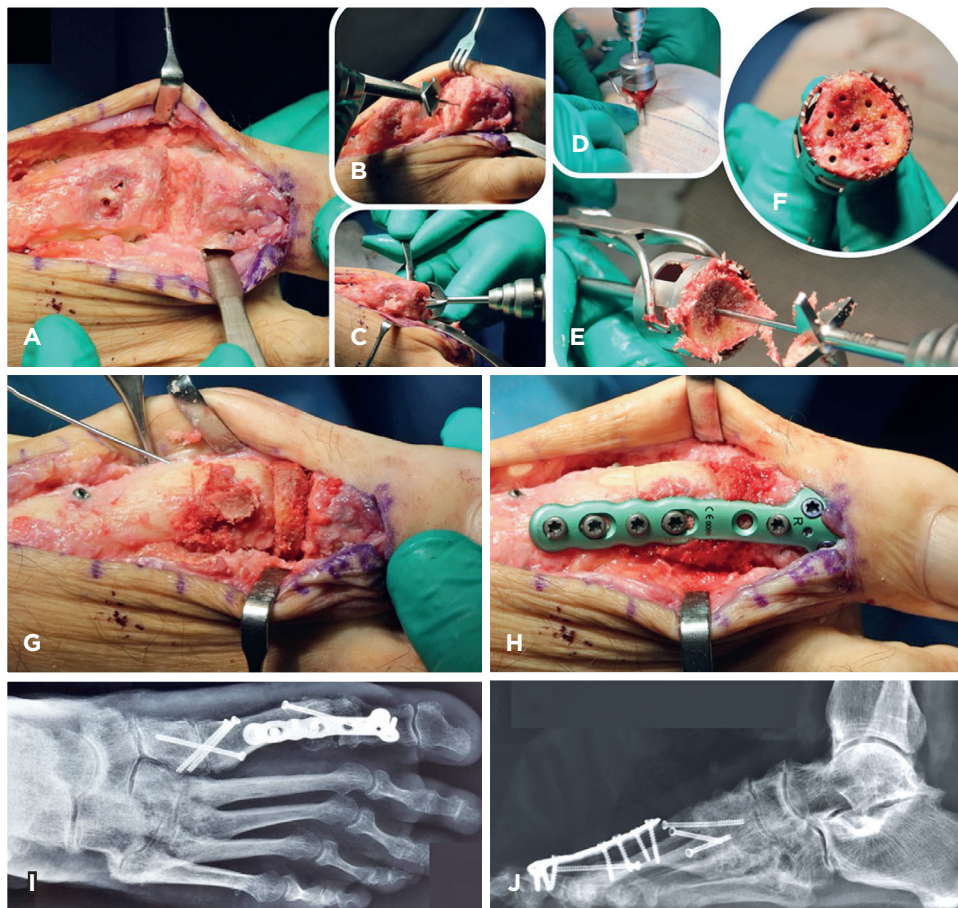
A. Dorsal view of the first metatarsophalangeal joint of a patient with pseudarthrosis. (B) Preparation of the hallux phalanx (C) Preparation of the first metatarsal head (D) Due to bone loss, an autologous graft was harvested from the iliac spine (E) Both surfaces of the iliac graft were prepared using the same reamers employed on the phalanx and metatarsal, creating one concave and one convex surface (F) Multiple perforations made in the autologous bone graft (G-H) After placing the bone graft into the bone defect, the construct was fixed with an oblique K-wire, followed by a dorsal plate and an oblique screw. In this case, the dorsal plate provided compression, while the oblique screw acted as a neutralization element (I-J). Radiographs at 6 months post-operatively, showing solid union at the arthrodesis site.
